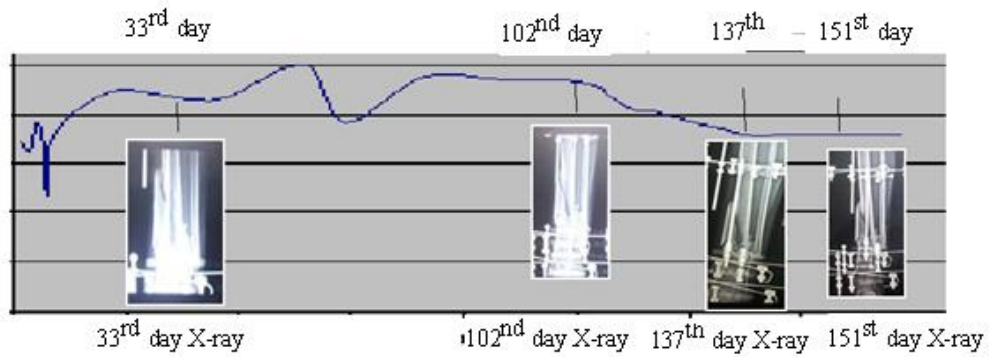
Progressive radiographs with time for case 2.
